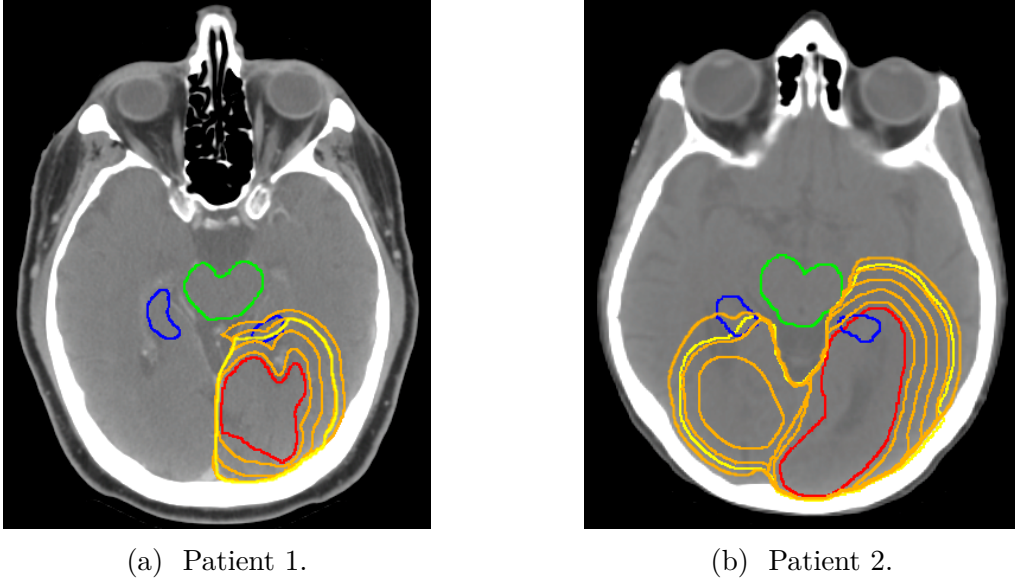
CT images of two GBM patients with a probabilistic definition of the CTV. Representative iso-probability contours are shown in orange. Other delineated contours indicate the clinically-approved CTV (yellow), GTV (red), hippocampi (blue) and brainstem (green).
